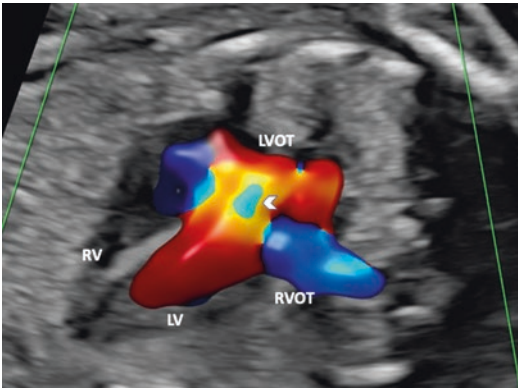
Color Doppler Nyquist effect. The image shows Radiant color flow mapping of the left ventricular outflow. Note the change of color from *red* to *yellow* with increasing velocity and then aliases to *blue* demonstrating the Nyquist effect. *LV* Left ventricle, *LVOT* Left ventricular outflow tract, *RV* Right ventricle, *RVOT* Right ventricular outflow tract
